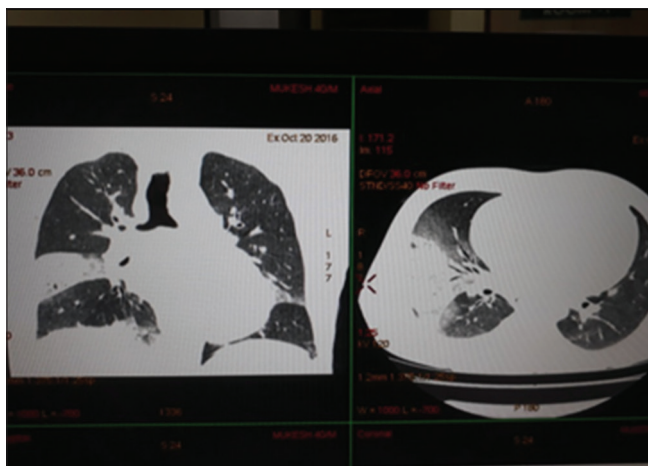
Computed tomography thorax coronal and axial lung window images showing consolidation in right lung
